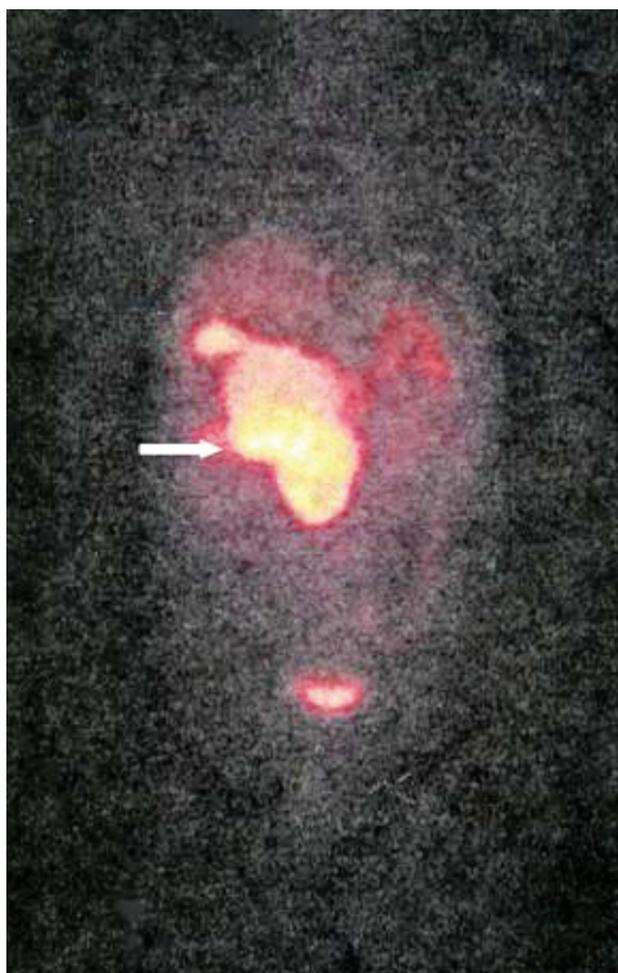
Somatostatin receptor scintigraphy shows an intense uptake corresponding to the pancreatic lesion (white arrow). There are no uptakes in the liver or the descending colon.
